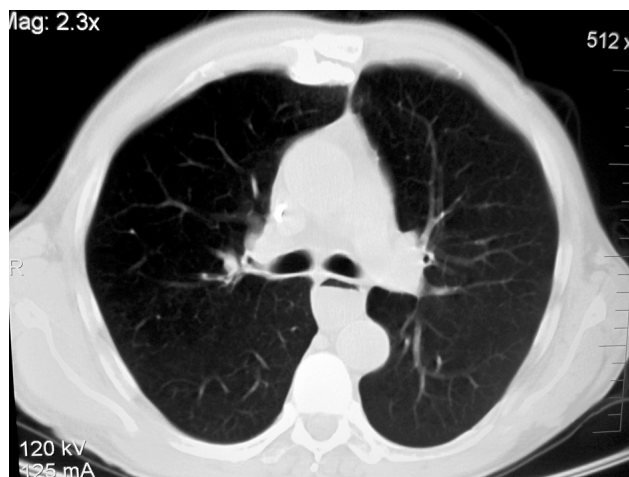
CT scan revealed no signs of lung cancer in the right hilum and prestenotic enlargement of the esophageal lumen
